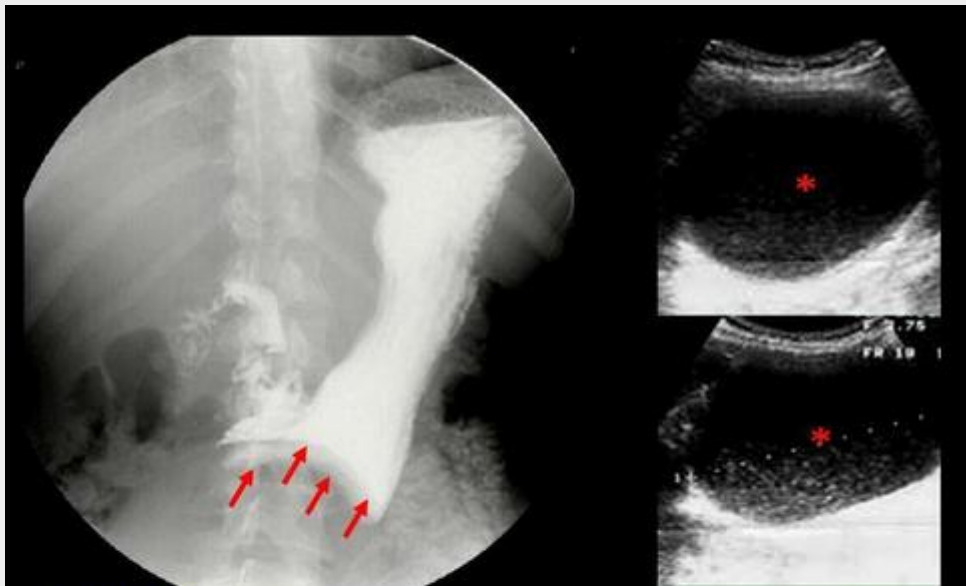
Duplication cyst of the gastric antrum. *Left* Barium meal in an upright position shows an oval, well defined, subtraction image in the gastric antrum (→). *Right* Abdominal Ultrasound shows a well defined anechoic oval lesion with floating debris (*).
